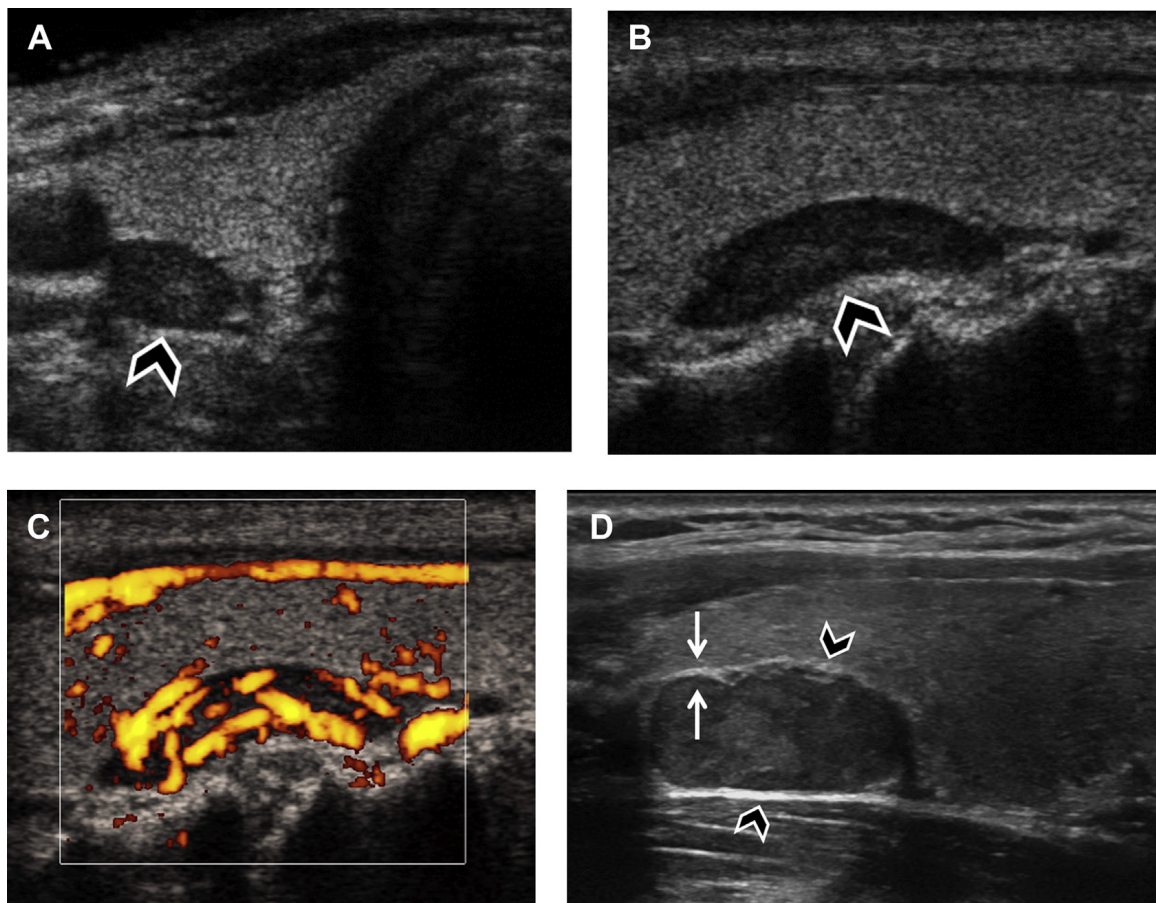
Typical appearance of superior parathyroid adenoma. Transverse (A) and sagittal (B, C) views show the typical grayscale and power Doppler appearance of a superior parathyroid adenoma (arrowheads). It is a solid, ovoid, well-defined, hypoechoic nodule immediately posterior to the thyroid gland with increased internal vascularity. (D) Sagittal view in a different patient shows another superior parathyroid adenoma (arrowheads). The white line (arrows) that separates the parathyroid adenoma from the thyroid helps distinguish this nodule from a thyroid nodule.
